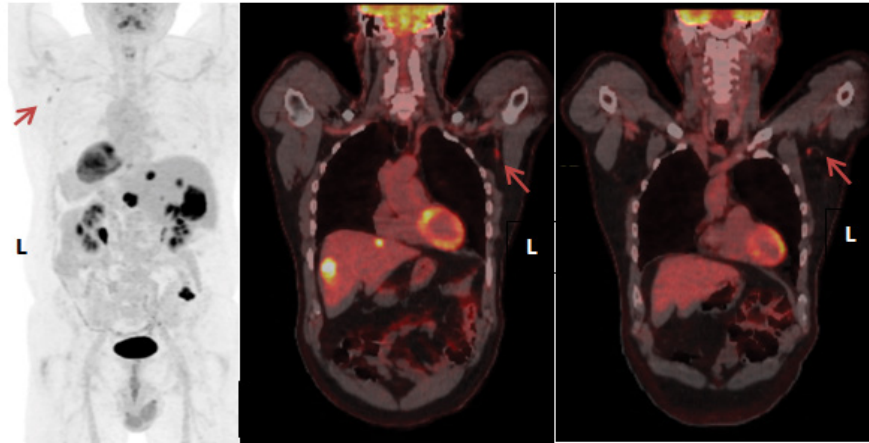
FDG PET-CT scan. A) MIP. B and C) Fused CT. Focally increased uptake in the left axillary lymph nodes (arrow head), coinciding with the recent COVID-19 vaccination.
